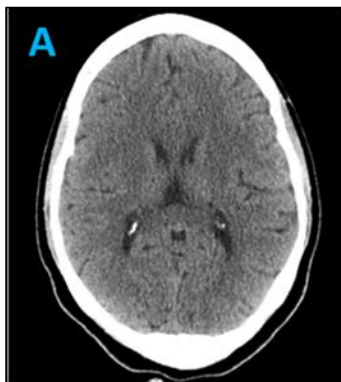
Non-contrast computed tomography (CT) scan of the head: demonstrates normal anatomy and no evidence of acute intracranial pathology; this includes a normal size of the brain for the patient's age, gray-white matter differentiation is maintained, no mass effect, no midline shift, or hydrocephalus
